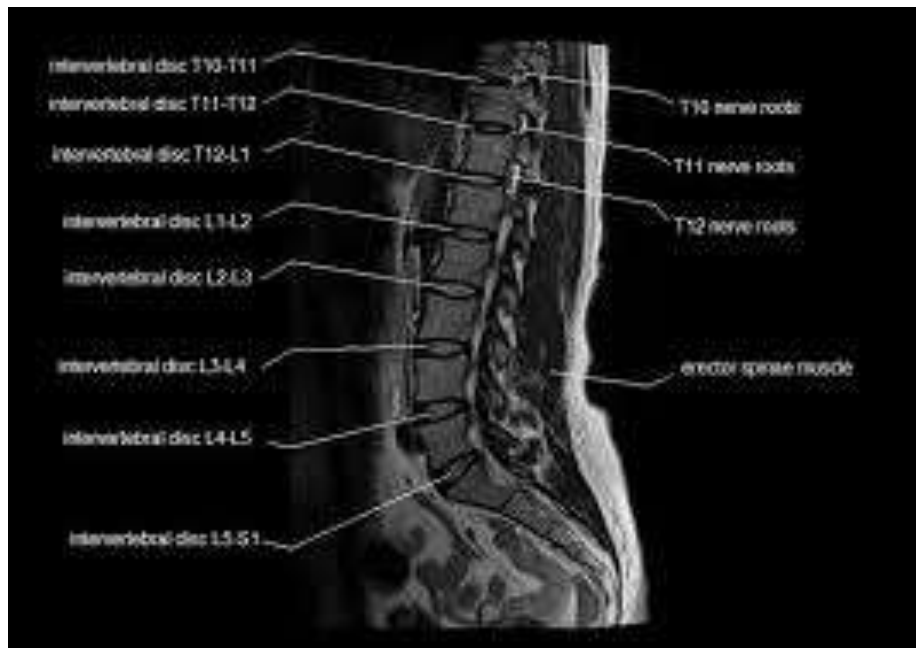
Normal Magnetic Resonance Imaging of the lumbar spine
